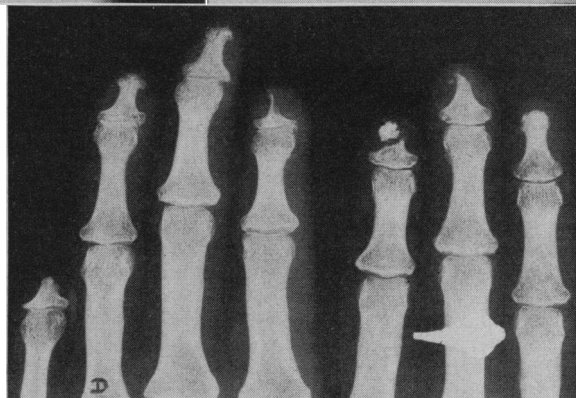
Scleroderma, with involvement of small bowel. The patient was a 42-year-old white woman. Raynaud's phenomenon had been present two years. There had been attacks of abdominal pain, nausea, vomiting and diarrhea for one and one-half years. Autopsy, six months after examination, showed generalized scleroderma. X-rays showed upper small bowel dilation and delay.
